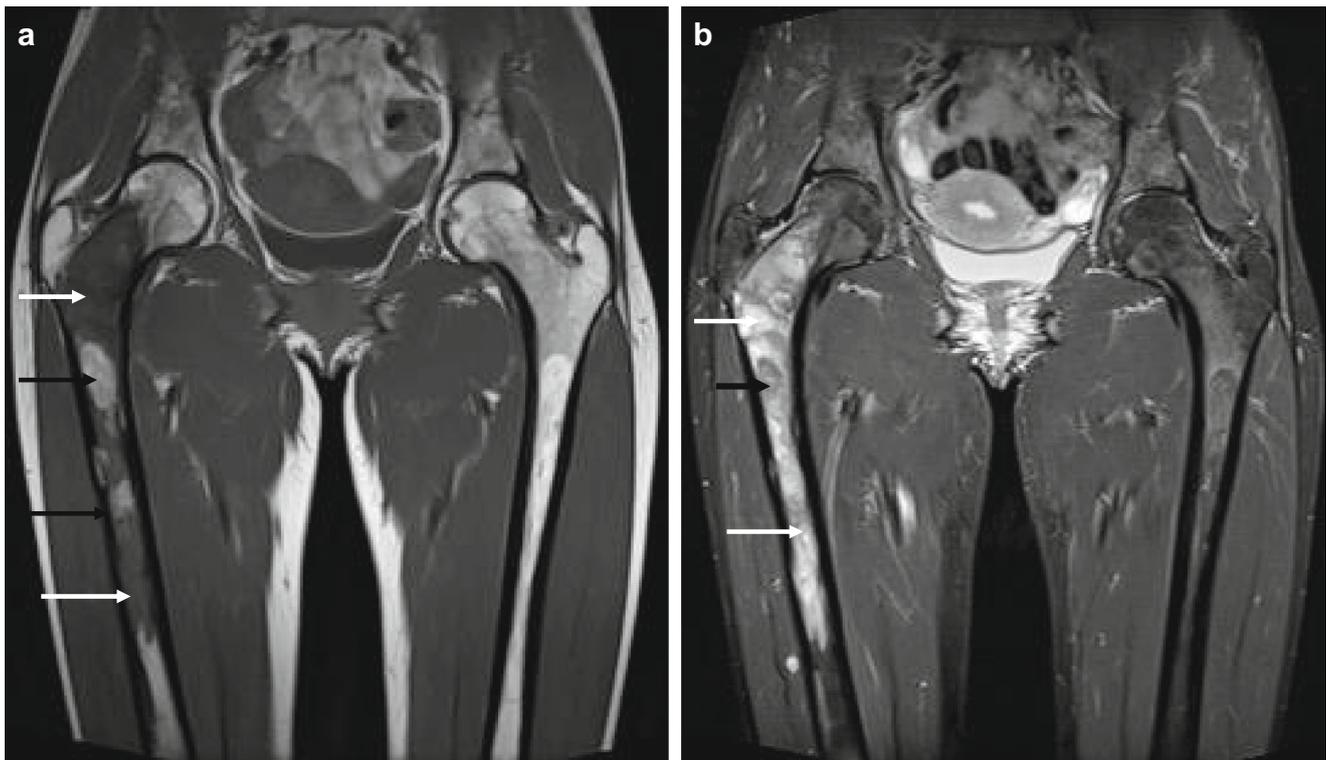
a Coronal T1-weighted MR image through the proximal femora showing heterogeneous intermediate to low intramedullary signal (arrow), with interspersed areas of fatty signal (black arrows). b
